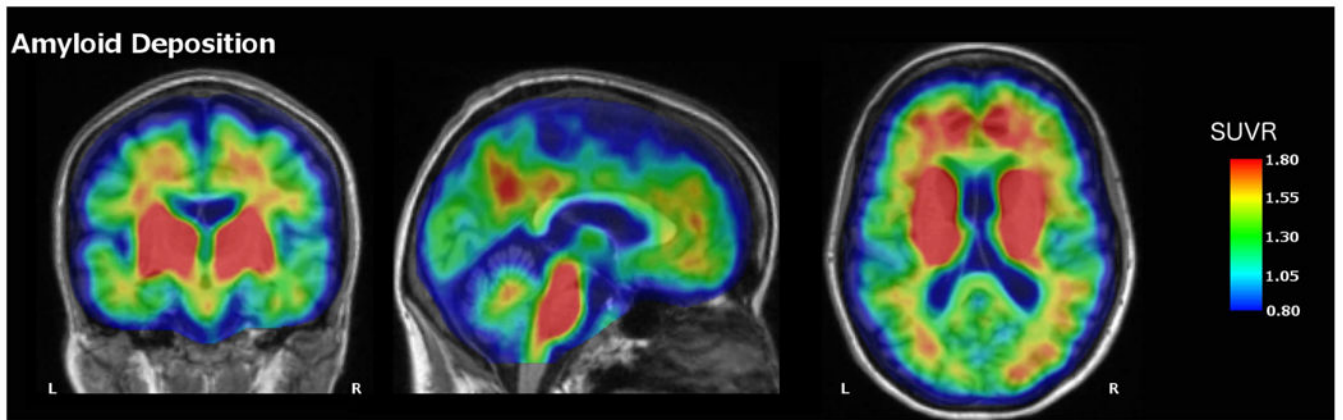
PiB-PET image for Case 1 depicting elevated amyloid deposition in the precuneus, medial prefrontal cortex, bilateral parietal cortex, as well as the basal ganglia and brainstem. Values represent SUVRs relative to cerebellar grey
